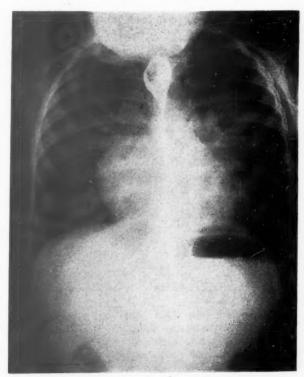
Patient G. A. S. A roentgenogram of the chest, with barium swallow.
